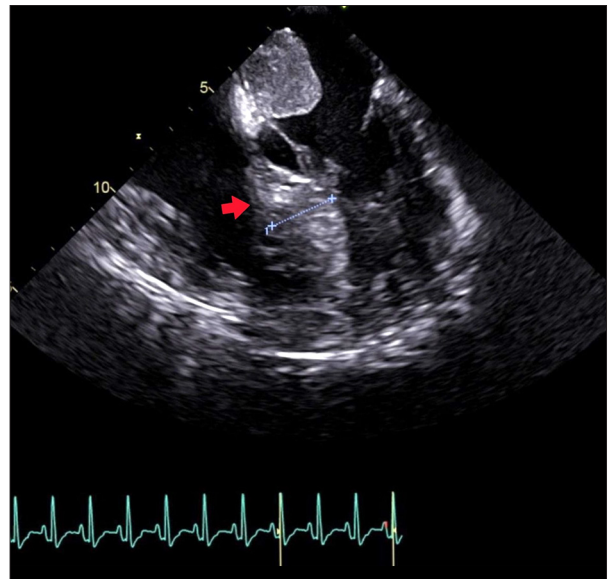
Echocardiogram with asymmetrical left ventricle concentric hypertrophy of the interventricular septum (25 mm).
